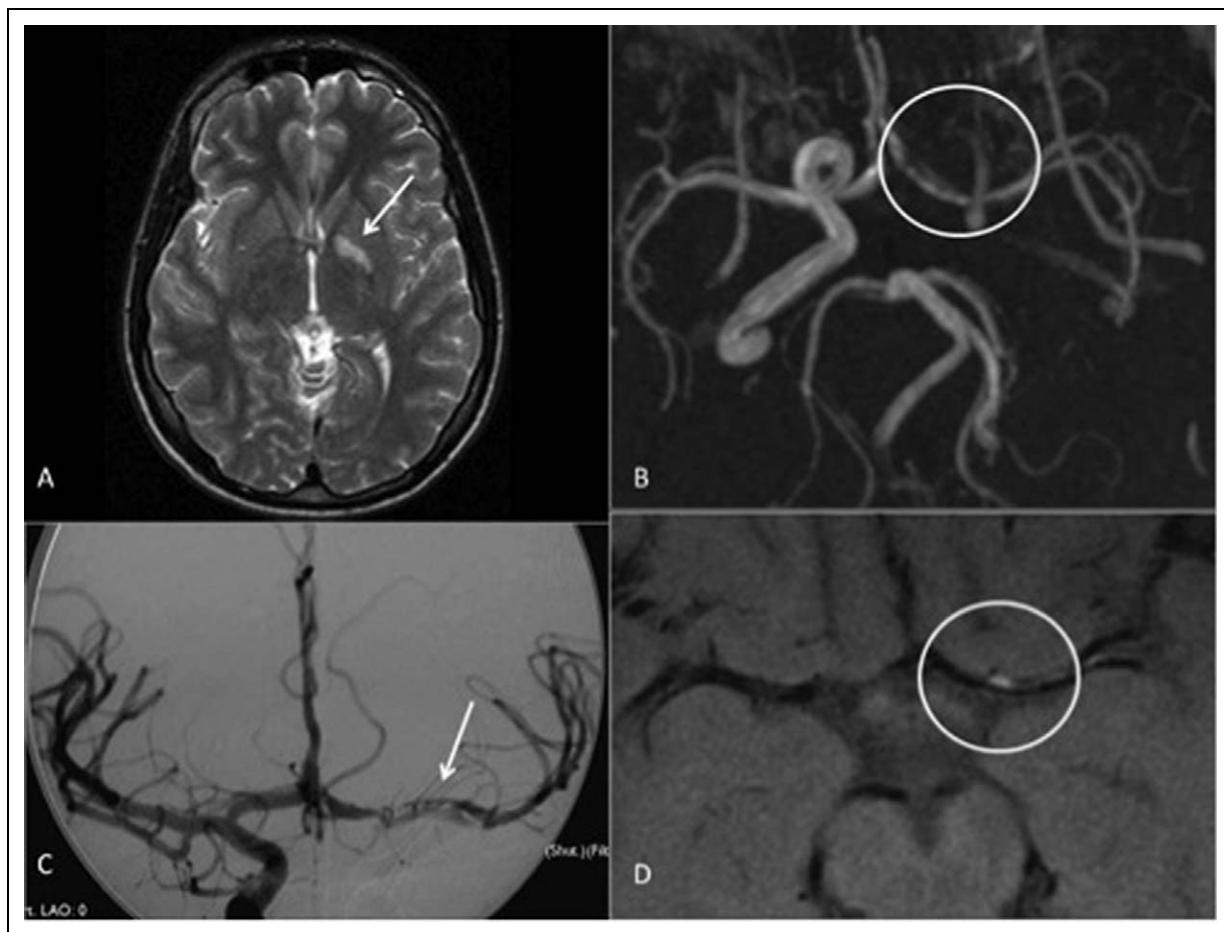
Case 4. A, Magnetic resonance imaging (MRI; arrow) showing left basal ganglia diffusion restriction. B, MR angiography nonvisualized of distal internal carotid artery and (circle) signal irregularity in left anterior cerebral artery and middle cerebral artery. C, Conventional angiography (arrow) left middle cerebral artery contrast filling defect suggestive of recanalizing thrombus or double lumen. D, MR vessel wall signal hyperintensity (circle) suggestive of intramural thrombus.
